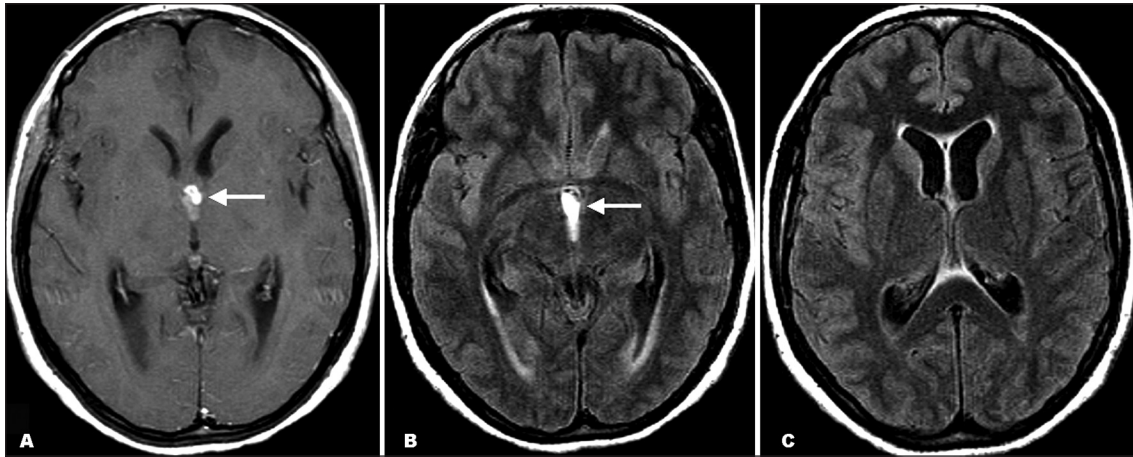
Axial T1-weighted post-gadolinium (A) and FLAIR (B and C) MR images show a third ventricle multiloculated mass showing mild ring enhancement after contrast administration (arrow). The lesion was obstructing the CSF flow (arrow), resulting in mild hydrocephalus and discrete ependymary transudation.
